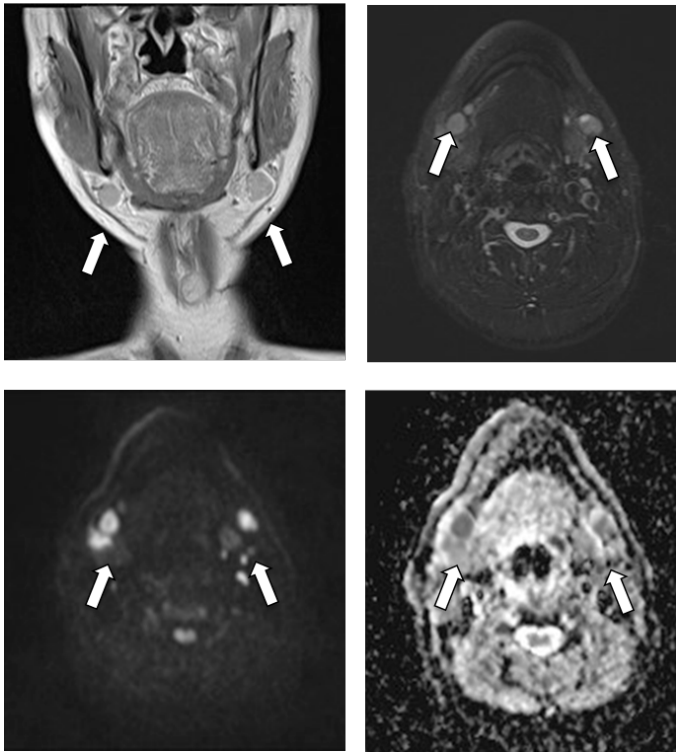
Metastatic lymph nodes from nasopharyngeal carcinoma. A. Abnormal lymph nodes in bilateral submandibular regions (arrows) show intermediate signal intensity in coronal T1-WI and B. in fat saturations axial T2-WI. C. These nodes are hyperintense on DWI (b value  $1000 \text{ sec}/\text{mm}^2$ ) (arrows). D. On ADC map they show low signal intensity (from  $0.64 \times 10^{-3} \text{ mm}^2/\text{sec}$  to  $0.86 \times 10^{-3} \text{ mm}^2/\text{sec}$ ) (arrows), compatible with restricted diffusion.
